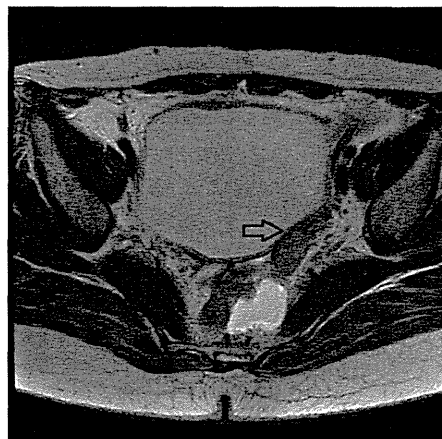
Magnetic resonance image showing a retroperitoneal mass measuring 4 cm × 1.5 cm at the left posterior aspect of the vaginal stump.
